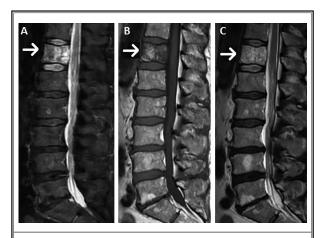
Pre-interventional MRI of T12 symptomatic hemangioma on (A) fat suppressed T2 weighted, (B) T1 weighted, (C) T2 weighted images.
